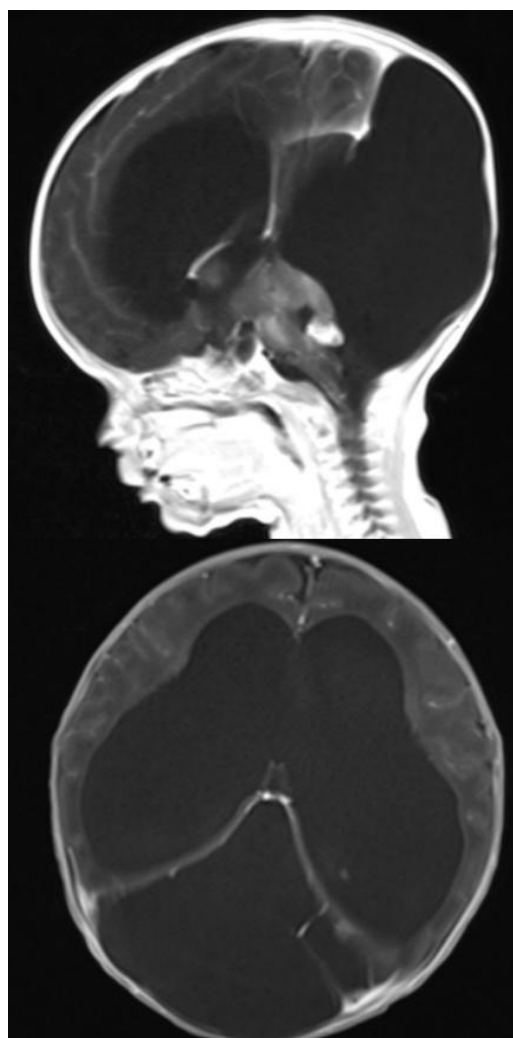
In brain MRI enhancing focus along the anterior aspect of the bilateral temporal lobe and an enhancing lesion at the foramen Magendi is consistent with leptomeningeal melanosis, appearing to be the reason for hydrocephalus. A large dorsal cystic lesion in the posterior fossa also seen with enhancement of bilateral cerebellar cortex and pons. Leptomeningeal melanoma in the foramen magnum region appears to be the cause of obstructive hydrocephalus.
